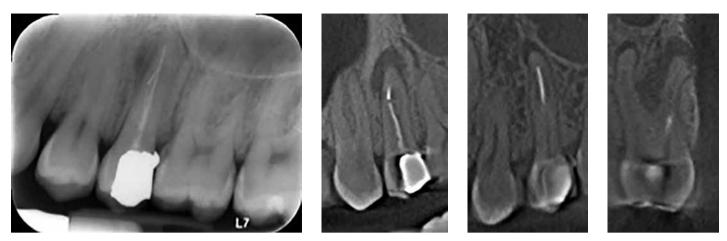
3C: 3A. Periapical showing a good root filling in the UL6. 3B. Six months later, the patient had mild pain on biting, and the periapical showed an increase in the lesion around the UL6 mesial root. 3C. The axial section of CBCT scan showed an unfilled MB2
